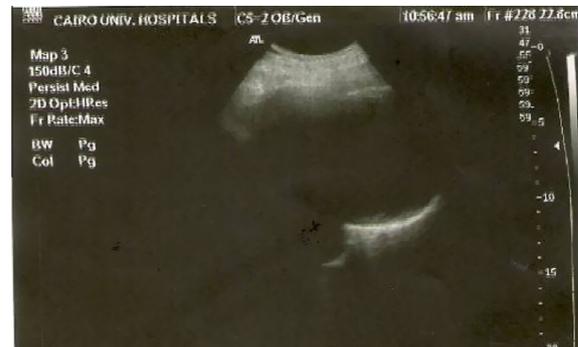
Ultrasound image of the pleural effusion with no evidence of thickening or masses.
